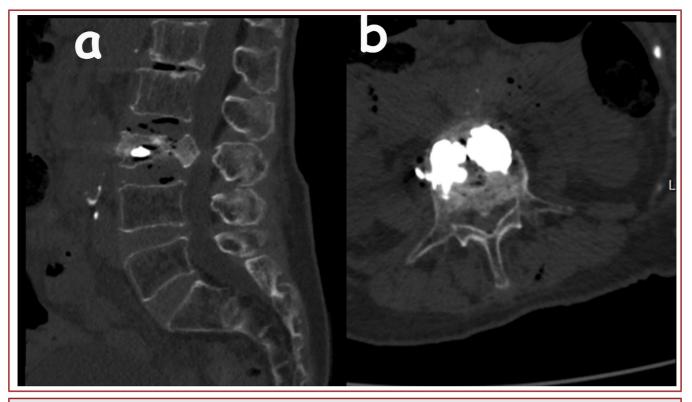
a) Computed tomography images on on sagittal and b) axial planes showing posterior wall retropulsion of the third lumbar vertebra after PVP.
